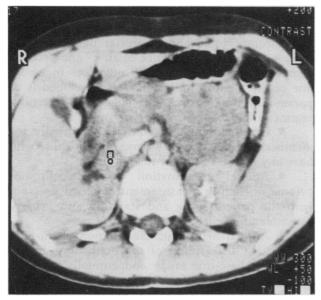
Computed tomography (CT) scan of upper abdomen of patient IV-9, showing pheochromocytoma of right adrenal gland (+), posterolateral to inferior yena cava.
